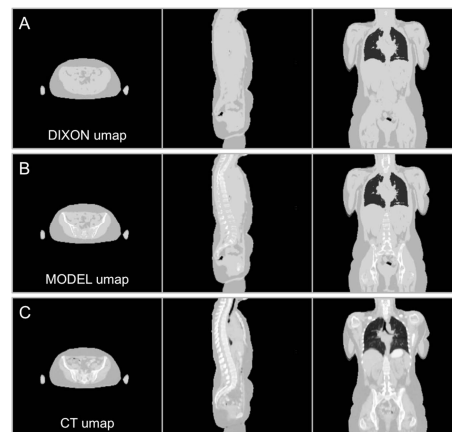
Dixon-based (A), model-based (B), and CT-based μ map (C) of one patient. Note that the model-based method (B) provides bone information with continuous LACs to the Dixon MR-based μ map.
